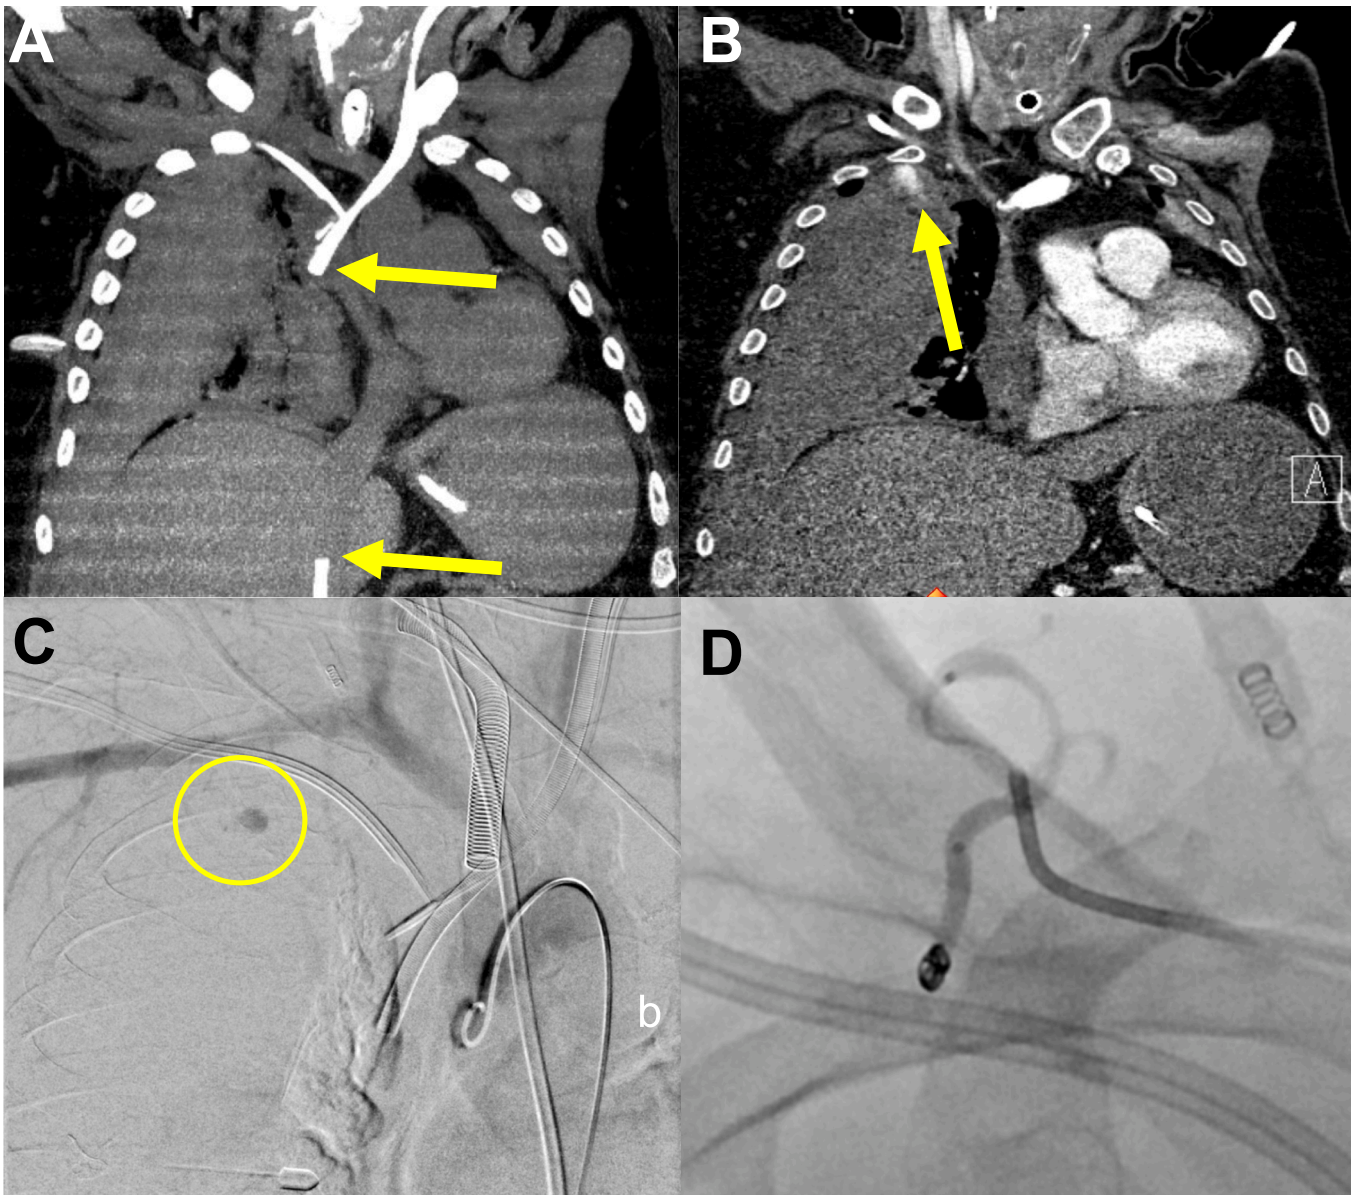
A 59-year-old male patient with a COVID-19 induced ARDS necessitating venous-venous-ECMO treatment (yellow arrow pointing at the cannulas in A, non-contrast enhanced CT) developed a spontaneous active arterial bleeding and large thoracic hematoma probably originating from a subclavian artery side branch (yellow arrow in B, contrast enhanced CT). After access via the right groin, the bleeding was confirmed via aortography and an origin from of a lateral branch of the thyrocervical trunk was identified as a bleeding source (C, yellow circle). By selective probing of the mentioned branch with a microwire and catheter, the catheter was advanced to the bleeding source. Combined particle and coil embolization was performed until stasis in the target vessel was reached (D).
